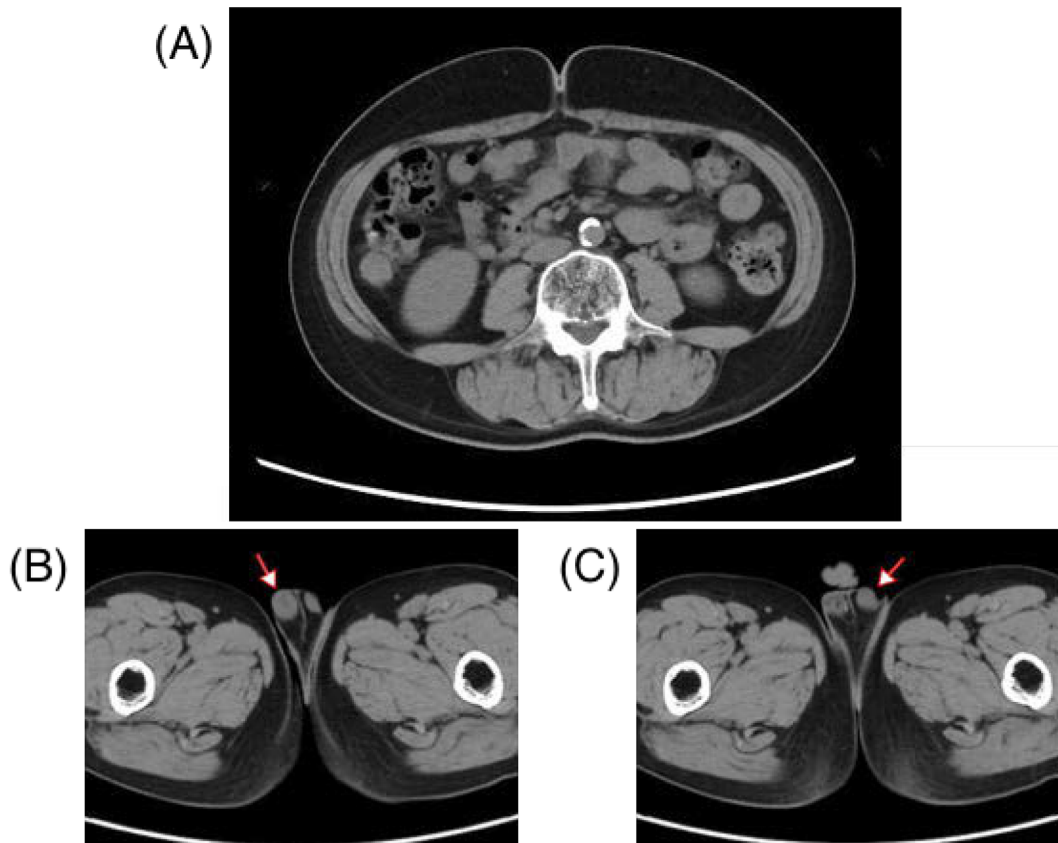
An X-ray CT image at the position of the omphalic part (A), the right testis (B), and the left testis (C).
